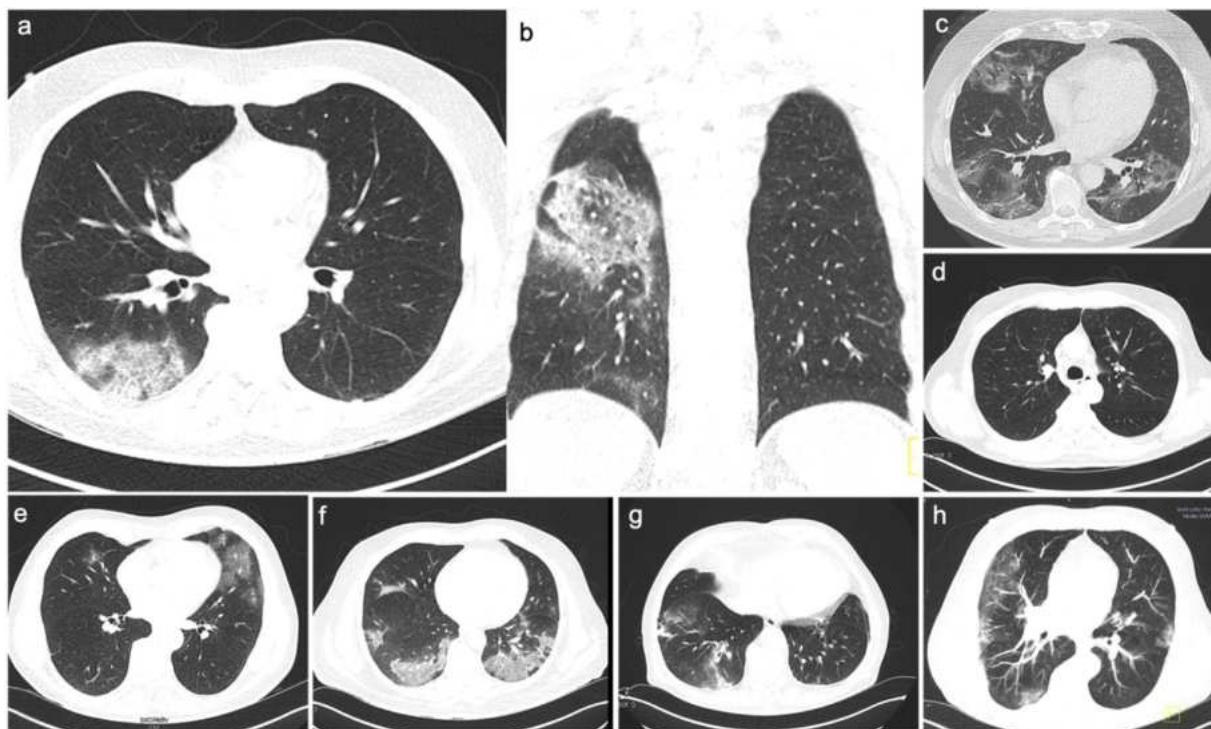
Lung imaging for all the patients. Computed tomography lung imaging was performed for all patients on admission (± 5 d). All patients showed signs of viral pneumonia, as evidenced from the images. (A,B) Images for patient 1 in the coronal and axial planes. (C–H) Images for patients 2–7, respectively, in the coronal plane. Predominantly bilateral ground glass opacification and typical COVID19-associated crazy paving areas are evident (C,F,H).
